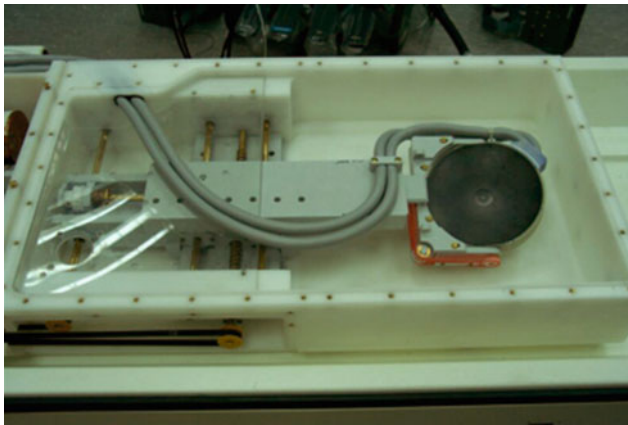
The inner workings of the ExAblate equipment that shows the ultrasound transducer connected to cables that help control the positioning of the transducer, (Image courtesy of InSightec)
